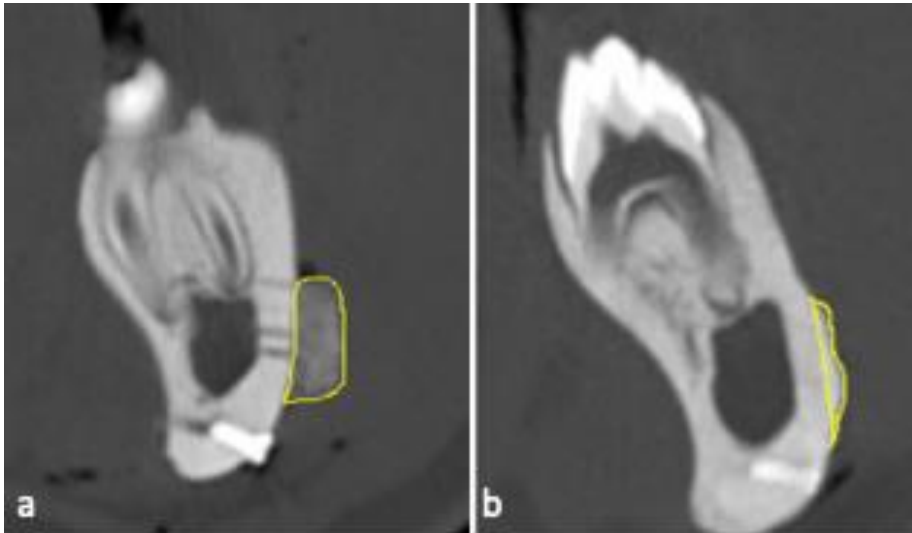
The augmented region outlined on the CT volume postoperatively
